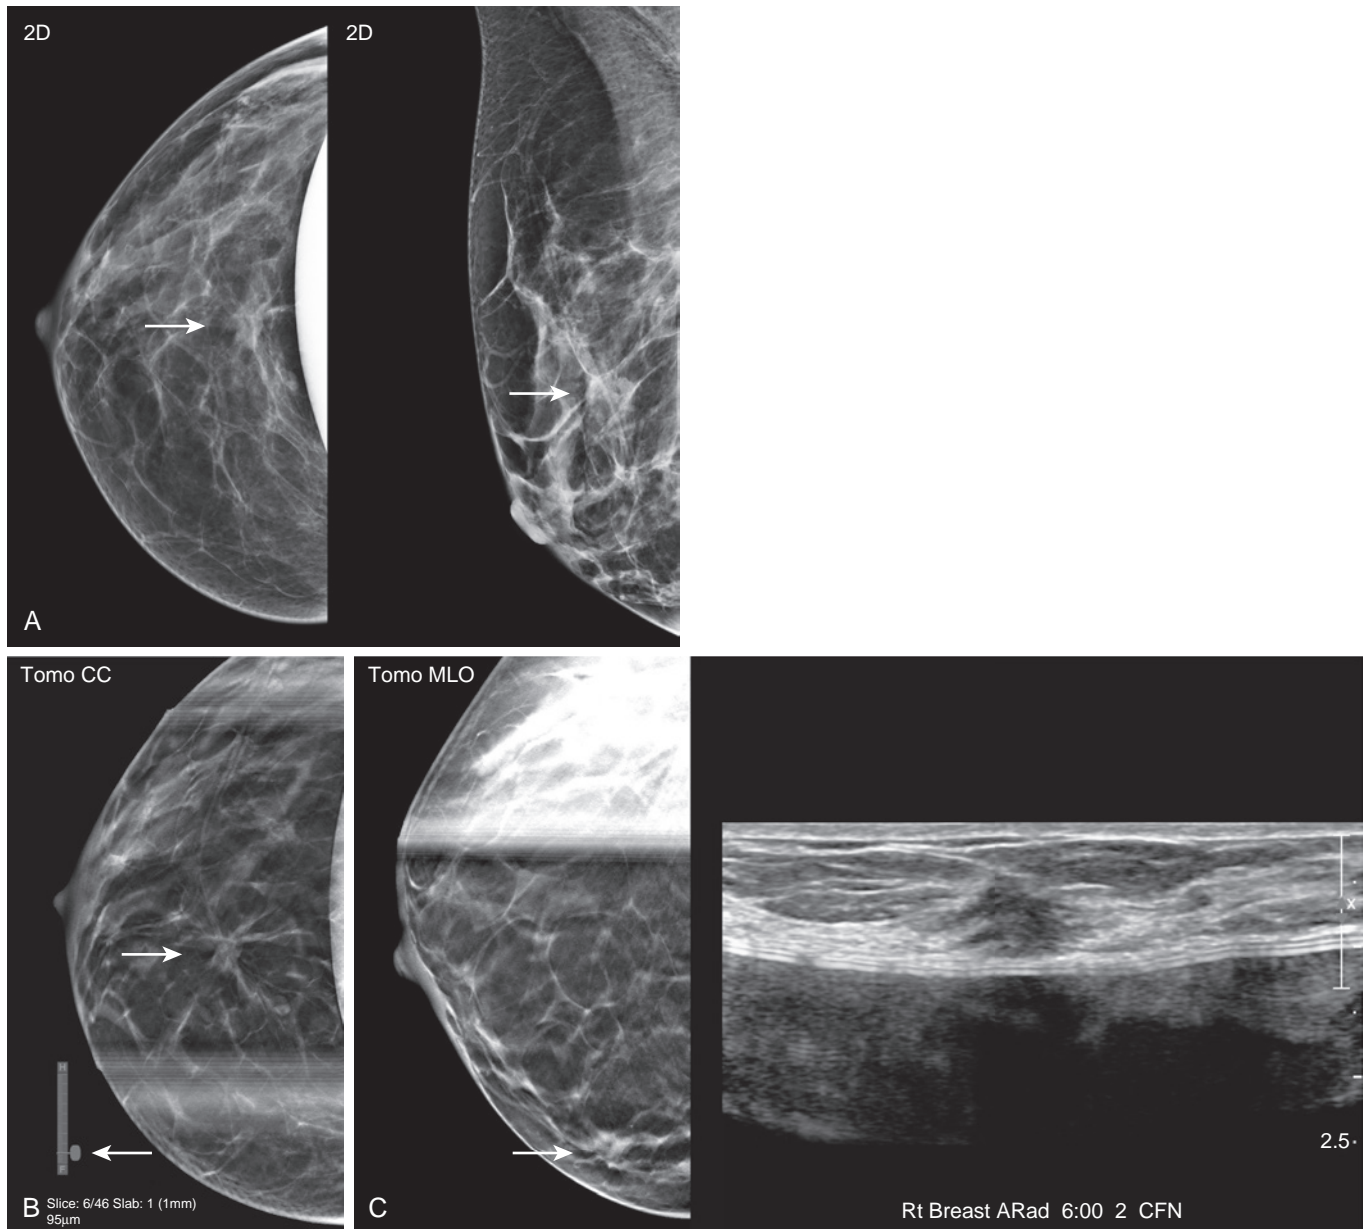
Implant and new breast cancer diagnosis. (A) A 43-year-old woman with retropectoral silicone implants undergoes routine two-dimensional screening mammography. The craniocaudal and mediolateral oblique implant displacement views suggest a central asymmetry, possibly in the upper breast (*arrows*). (B) A diagnostic spot compression craniocaudal tomosynthesis slice identifies an irregular spiculated mass, but in the lower and not the upper breast, as shown by the slice location indicator (*arrows*). (C) The mass is confirmed in the lower breast on a spot compression mediolateral oblique tomosynthesis slice. Targeted ultrasound also shows the irregular hypoechoic mass at the 6-o'clock position, superficial to the implant. Final diagnosis is adenoid cystic carcinoma, 1.5 cm, triple negative, with negative sentinel lymph node biopsy.
